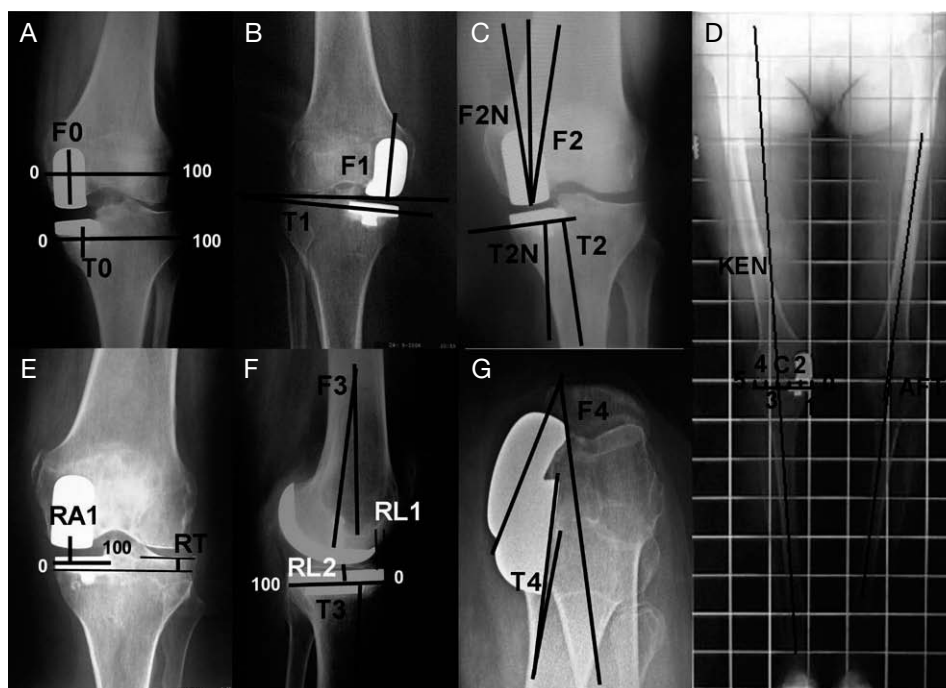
Different x-ray assessments performed. See descriptions in the text (A-G).
